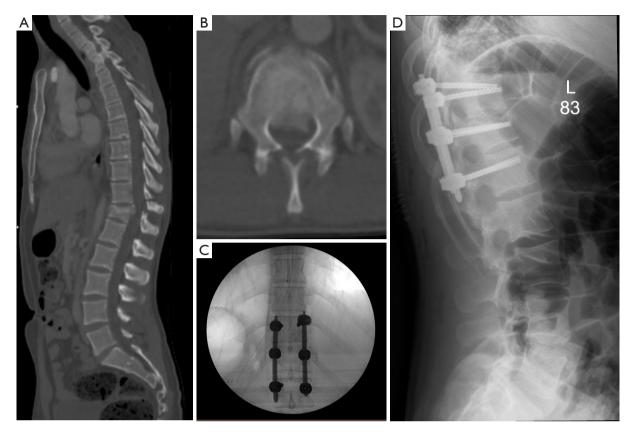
Case of 22-year-old that presented with a flexion distraction injury and T12 burst fracture with canal retropulsion. (A) Mid-sagittal showing flexion-distraction injury of T11 posterior elements and a T12 burst fracture; (B) axial CT of T12 showing retropulsion into spinal canal; (C) intra-operative anterior-posterior fluoroscopy; (D) post-operative lateral X-ray of thoracolumbar spine.
